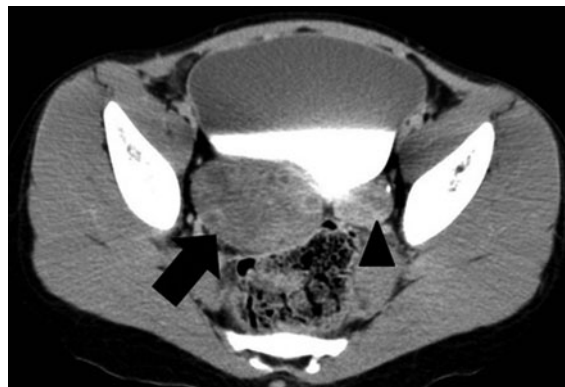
Ovarian torsion in a 13-year-old-female with right pelvic pain. Axial contrast-enhanced CT image shows a well-defined enlarged ovary with multiple peripherally enhancing subcapsular cysts (*arrow*) located posterior to the contrast filled bladder. Note the normal ovary on the left side (*triangle*)
